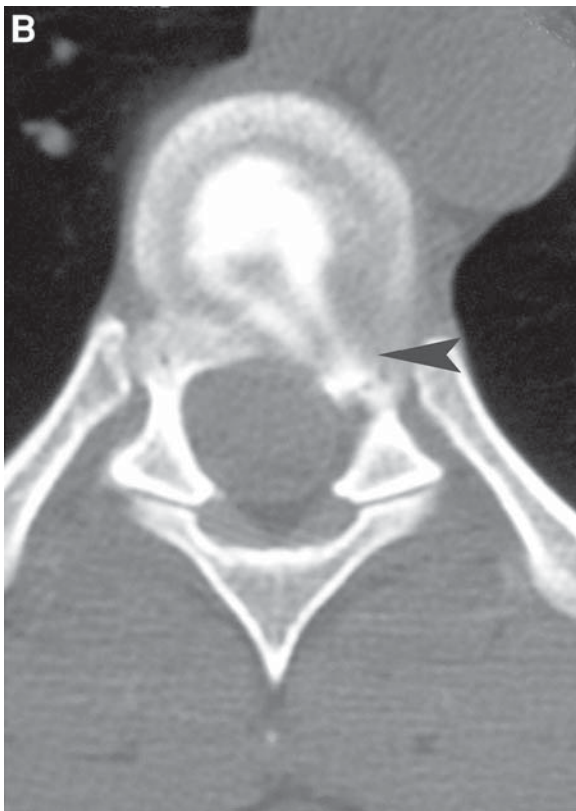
Thoracic spine discogram morphology. (A) Axial CT image shows contrast opacifying a peripheral annular tear and extending posteriorly into a focal central protrusion (*arrowhead*). This should be distinguished from contrast extravasating along the needle tract (*arrowhead* in B). Adapted with permission from Carrino JA and Morrison WB. *Discography: current concepts and techniques*. Appl Radiol. 2002; 31: 32–40.
